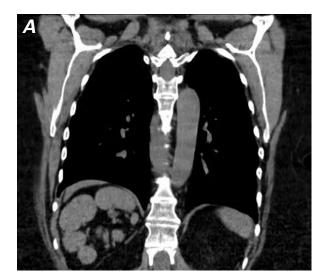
Computed tomograms show A) right-sided polysplenia and B) horizontal configuration of the liver.
